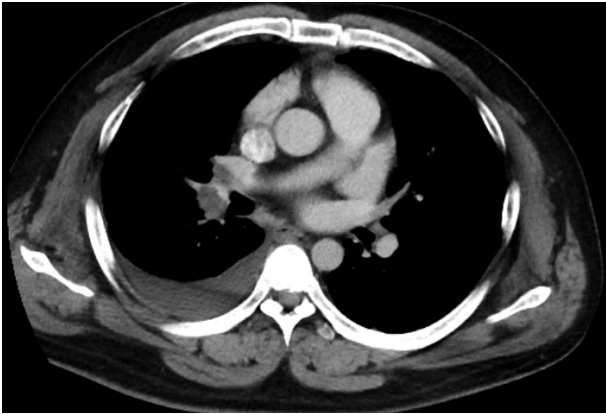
Chest computed tomography showed pulmonary thromboembolism of the right main pulmonary artery and right middle and lower lobar artery.
